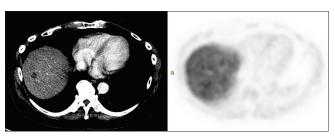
Axial computed tomography and attenuation-corrected positron emission tomography images of the latest fluorine-18 choline positron emission tomography/computed tomography
